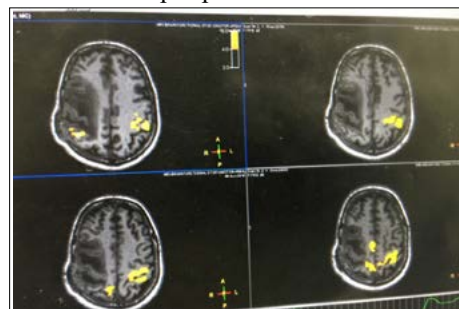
Functional MRI scan Brain 14 months after head injury
